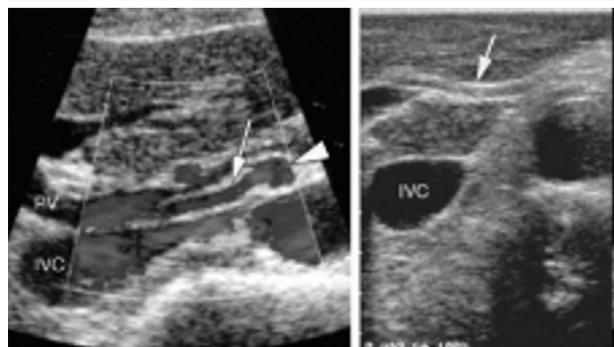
Replaced right hepatic artery. Intraoperative color Doppler US image shows a replaced artery (arrow) that arises from the superior mesenteric artery (arrowhead) and courses between the portal vein (PV), which is anterior to it, and the more posteriorly located vena cava (IVC).
